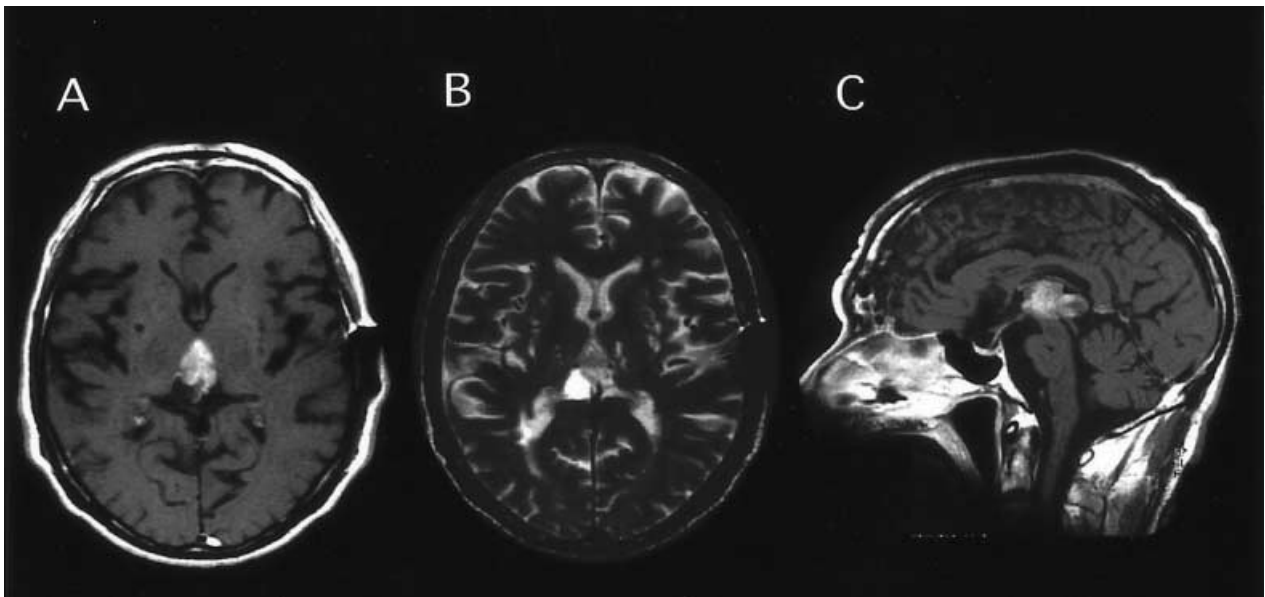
Figures A, B, and C are Magnetic resonance images on admission. T1-weighted images with gadolinium-diethylenetriaminepenta-acetic acid administration, the axial view (A) and the sagittal view (C), the tumour shows heterogenous enhancement estimated as 3 cm in the length. T2-weighted image (B) shows a high intensity area indicating a cystic component of the tumour
